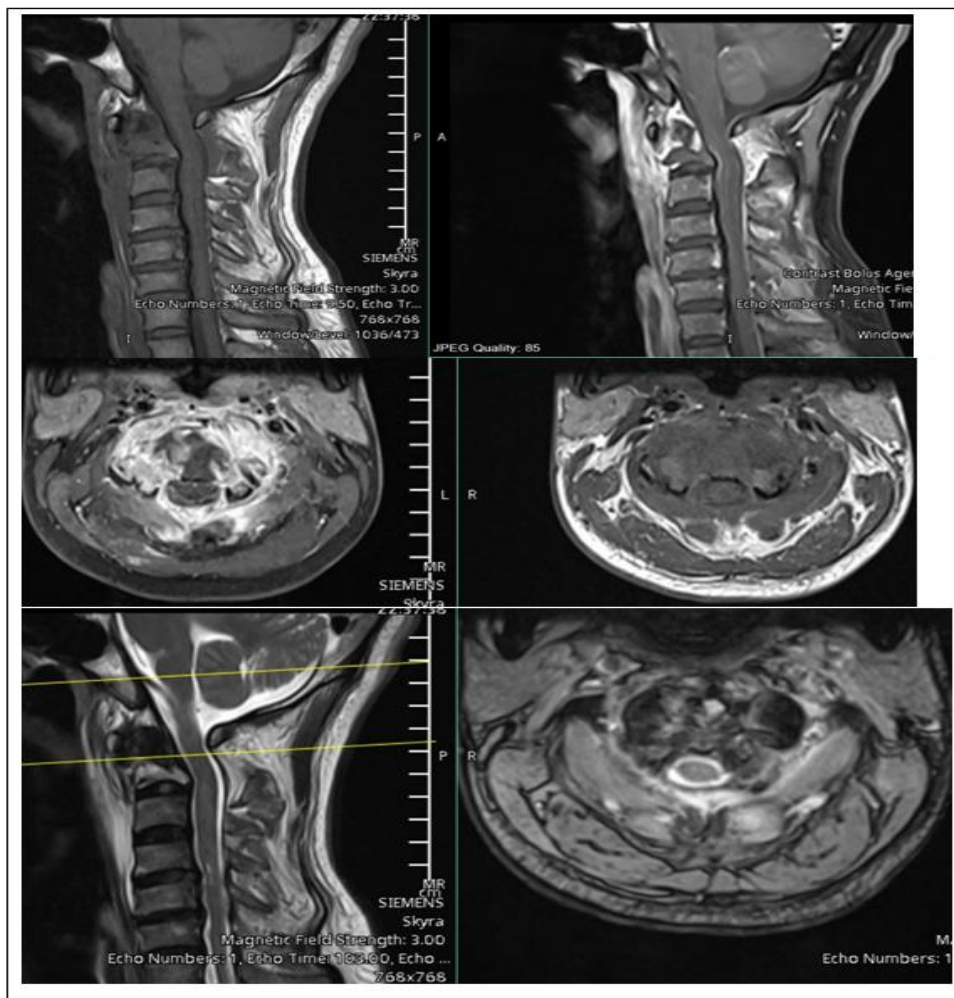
Cervical spine MRI showing prominent C2 vertebrae destruction and reduction in the height of its body. Extensive soft tissue swelling with heterogeneous post-contrast enhancement is seen in the prevertebral soft tissue, extending to the retro/parapharyngeal space with no definite collection. Similar but to a lesser extent soft tissue swelling and enhancement were noted in the posterior paraspinal muscles. Increase in the distance between the C1-C2 spinous processes, with partial posterolateral spondylolisthesis of C2 over C3 was also seen. Linear high signal intensity was seen in the cervical cord at the level of C4-C5 with volume loss suggesting myelomalacia.
